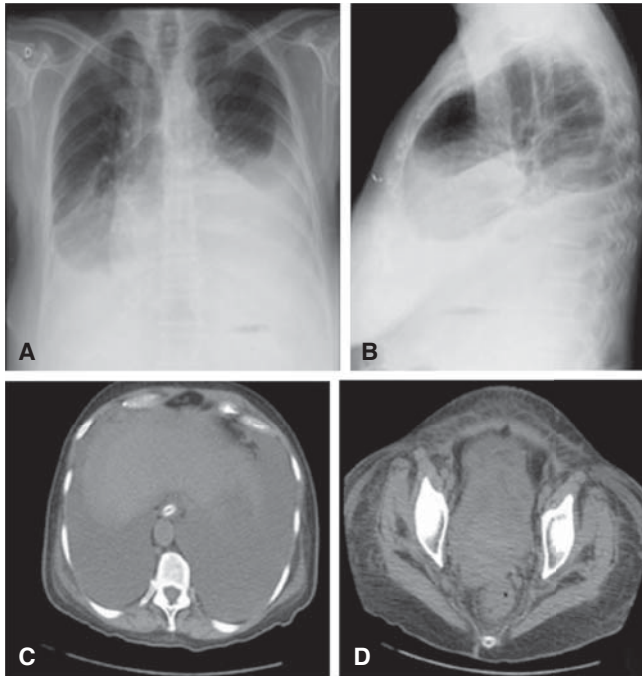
A and B: Chest radiograph showing accentuated bilateral pleural effusion; and abdominal CT revealing massive ascites (C); and voluminous hypogastric mass with areas of necrosis, bilaterally involving adjacent organs and local lymph nodes (D).
